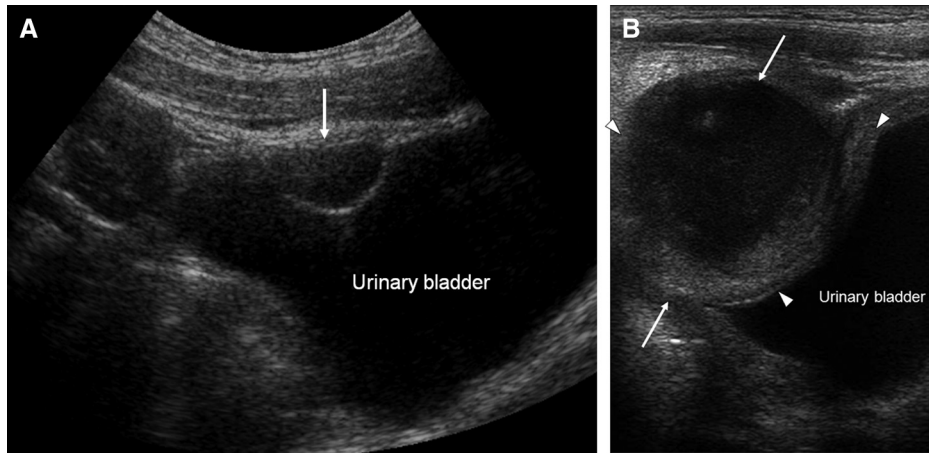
(A) An urachal cyst; longitudinal sonogram of suprapubic region; a small cystic lesion is present in the anterosuperior anterior aspect of the urinary bladder, suggestive of small urachal cyst (arrow). (B) Infected urachal cyst; longitudinal sonogram at the suprapubic region of another patient; a mixed hypo- and anechoic mass in the suprapubic region, with low-level echoes inside the lesion suggestive of pus formation; adjacent soft-tissue inflammatory change with urinary bladder wall thickening is also noted (arrowheads); with the typical position and appearance, the features are compatible with infected urachal cyst (arrows).
